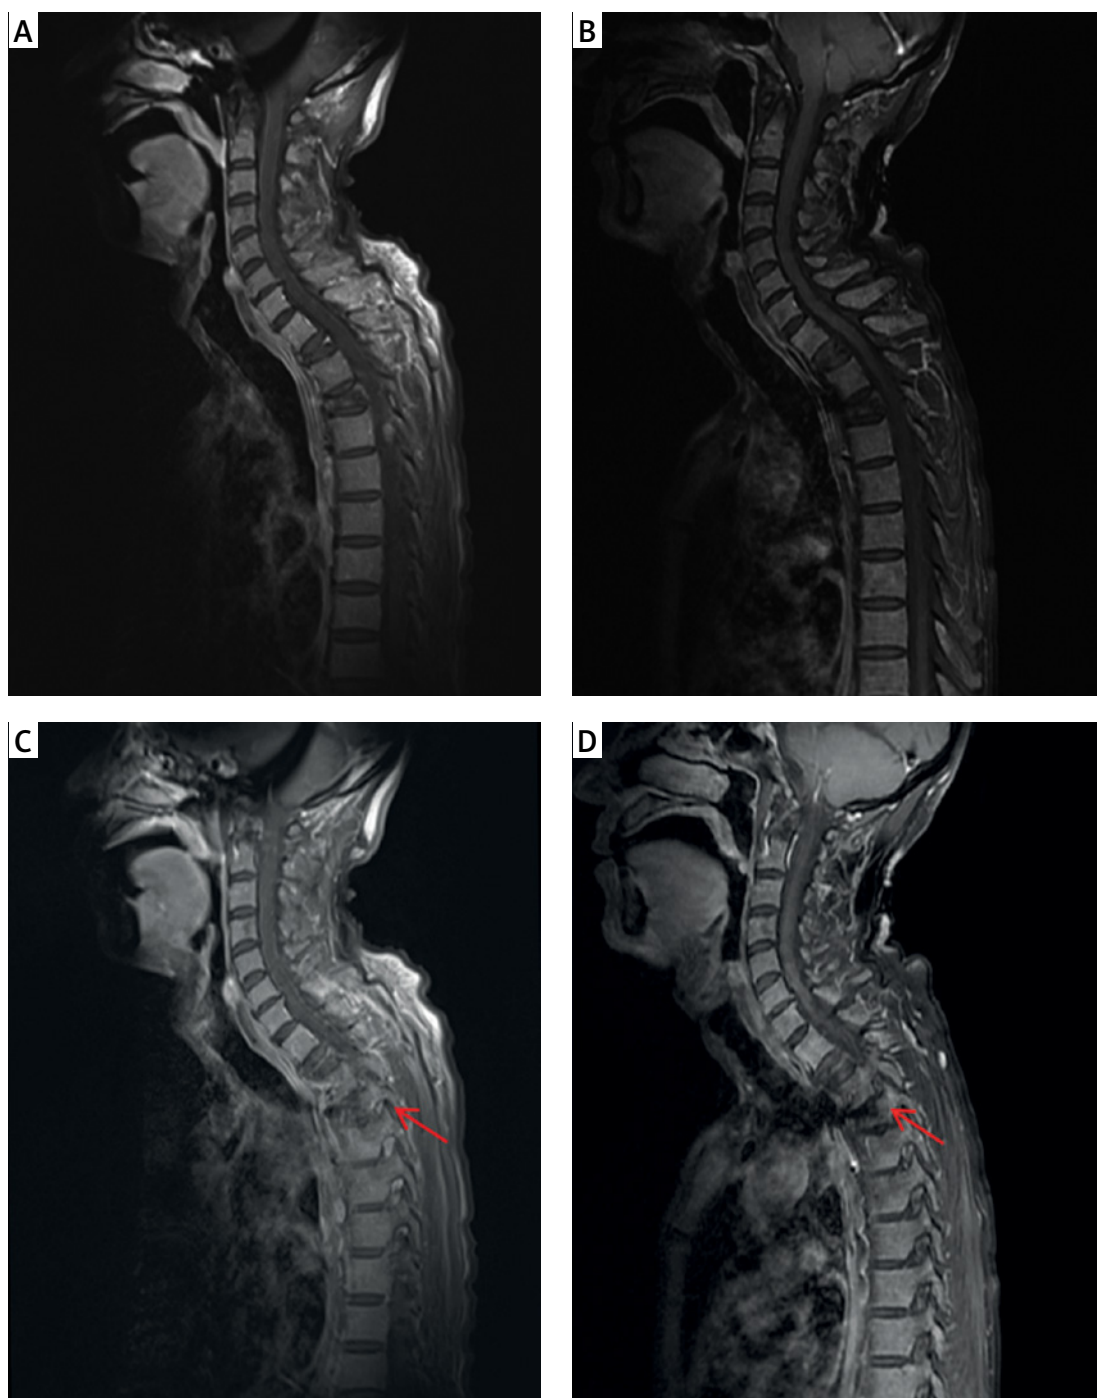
Contrast-enhanced MRI of the whole spine showed that leptomeningeal enhancement throughout the spinal cord was markedly reduced after teclistamab treatment (A and B), and the space-occupying lesion in the left neural foramen at T5/6 also significantly shrank (C and D)
